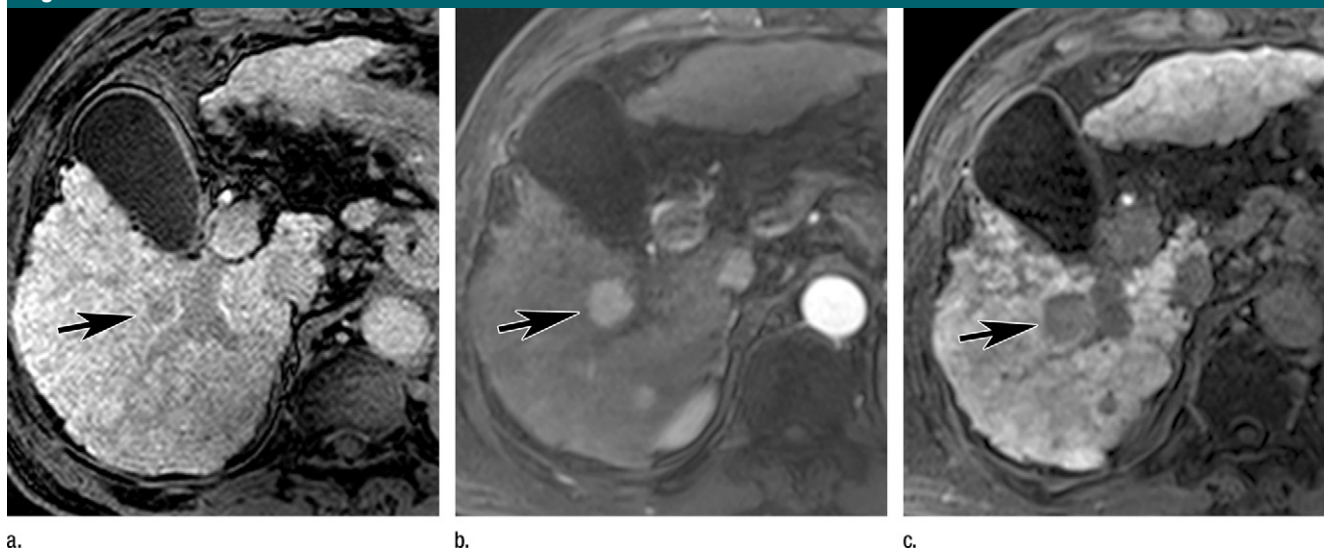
MR images in 63-year-old man with hepatitis B–related cirrhosis. (a) Hepatobiliary phase image of initial MR imaging shows small hypointense nodule (arrow) that was not visible on unenhanced and dynamic images (not shown). Because of inability to exclude the possibility of HCC, follow-up was recommended. During imaging analysis, the lesion was not appreciated as HCC on precontrast and dynamic MR images because of its small size. (b) Arterial phase and (c) hepatobiliary phase MR images obtained 9 months later show that the nodule (arrow) has increased in size and shows enhancement.
